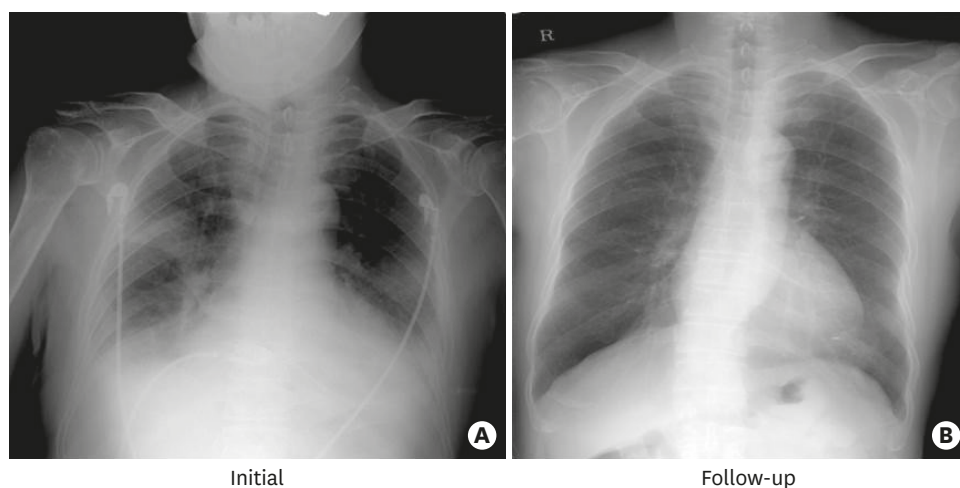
Chest X-ray on admission (A) and at discharge (B). Note the disappearance of bilateral pleural effusion and pulmonary congestion at discharge.
